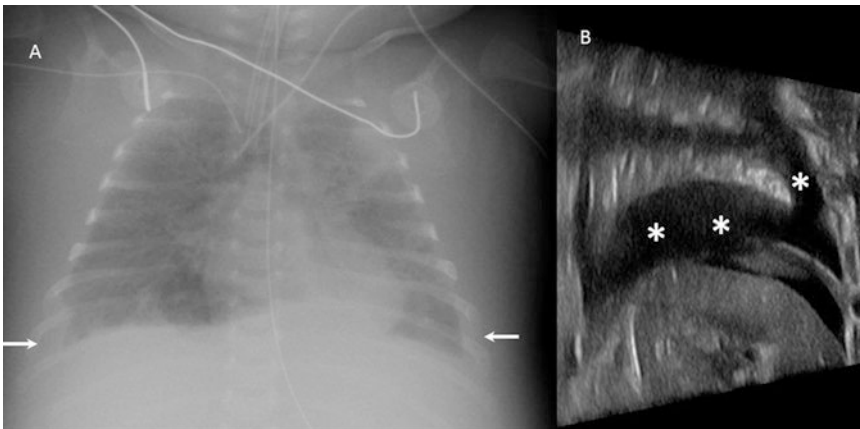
Neonate with large left-sided pleural effusion. Supine radiograph of the chest shows diffuse left lung haziness with a moderate left pleural effusion (*arrows*). Note the contralateral mediastinal shift and the compressive right upper lobe atelectasis
